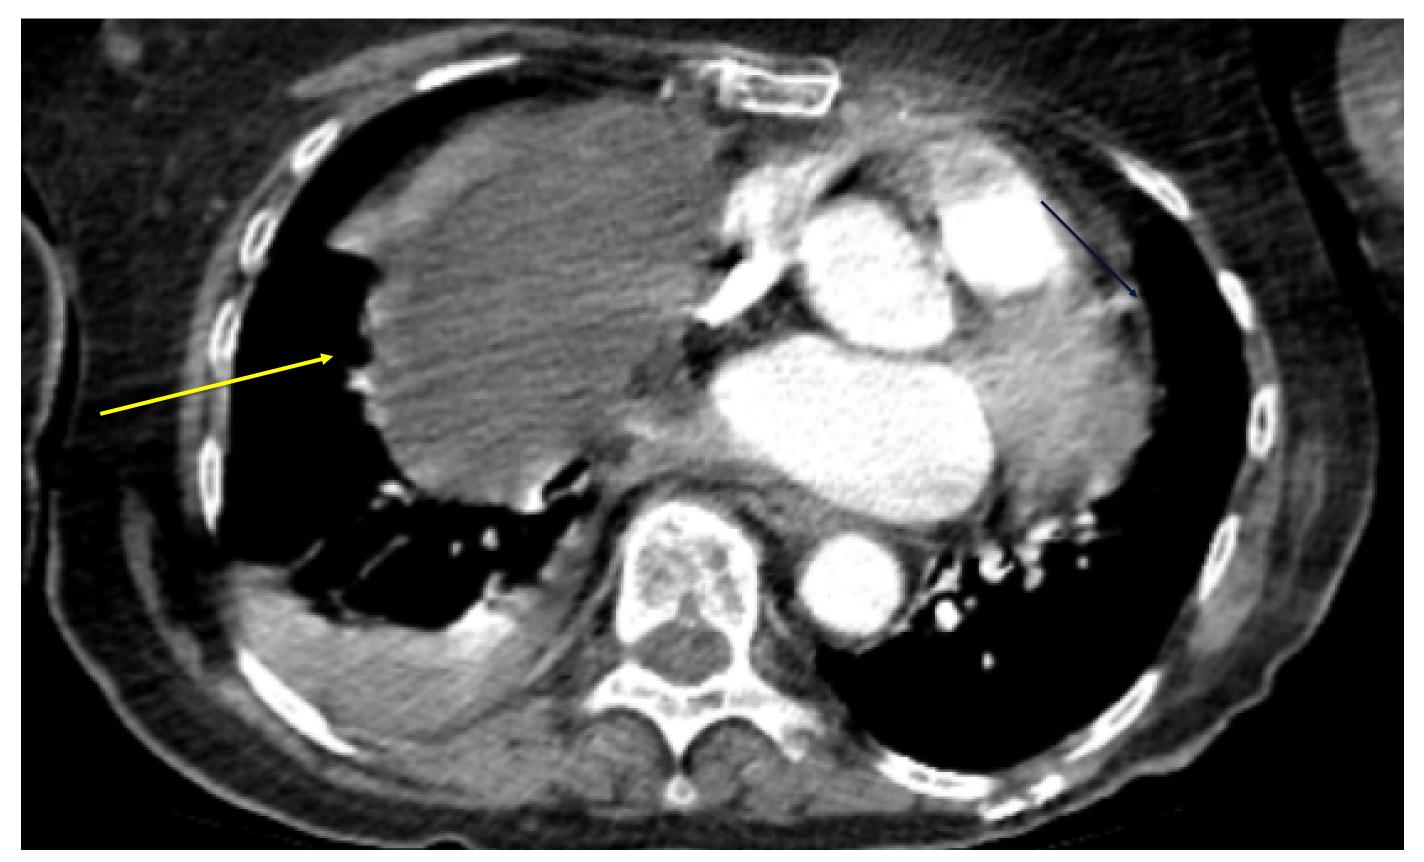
CTA chest obtained mid-autumn, 2022. Compared to PET/CT from two months prior, the 2.5 x 2.5cm hypermetabolic pericardial mass is now 6.0 x 8.3cm. It appears necrotic and is most likely metastatic/malignant.
